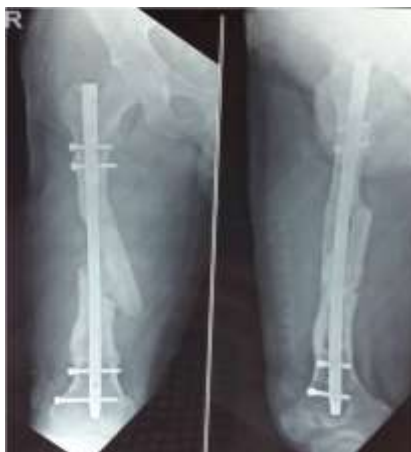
(b): AP and Lateral radiographs of femur after exchange nailing
